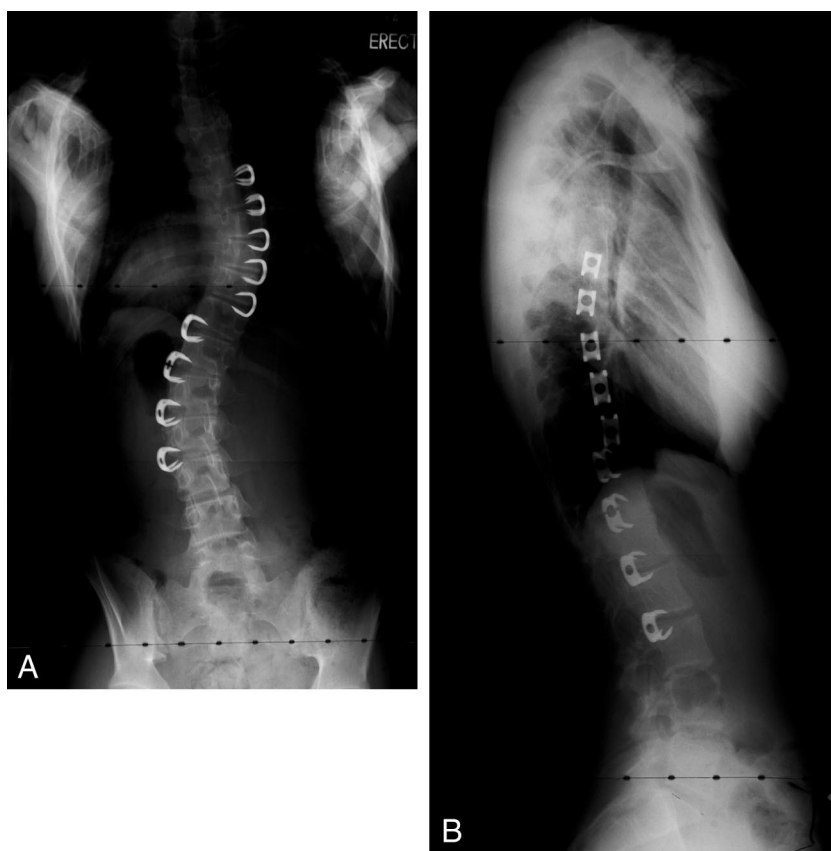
A, B, A 13-year-old female presents with a double curve (thoracic curve: 30°, lumbar curve: 28°). She underwent vertebral body stapling with essentially no correction, with the thoracic curve measuring 31° and the lumbar curve 27° at her first postoperative erect radiograph. On her 18-month follow-up AP and lateral radiograph, it was noted that she had a broken staple at the T12–L1 disc space. The staple did not dislodge. Her thoracic curve progressed to 40° and lumbar curve to 35°; however, it was felt that the staple did not lead to the progression of the curve, due to the fact that there was minimal to no displacement of the broken staple.
